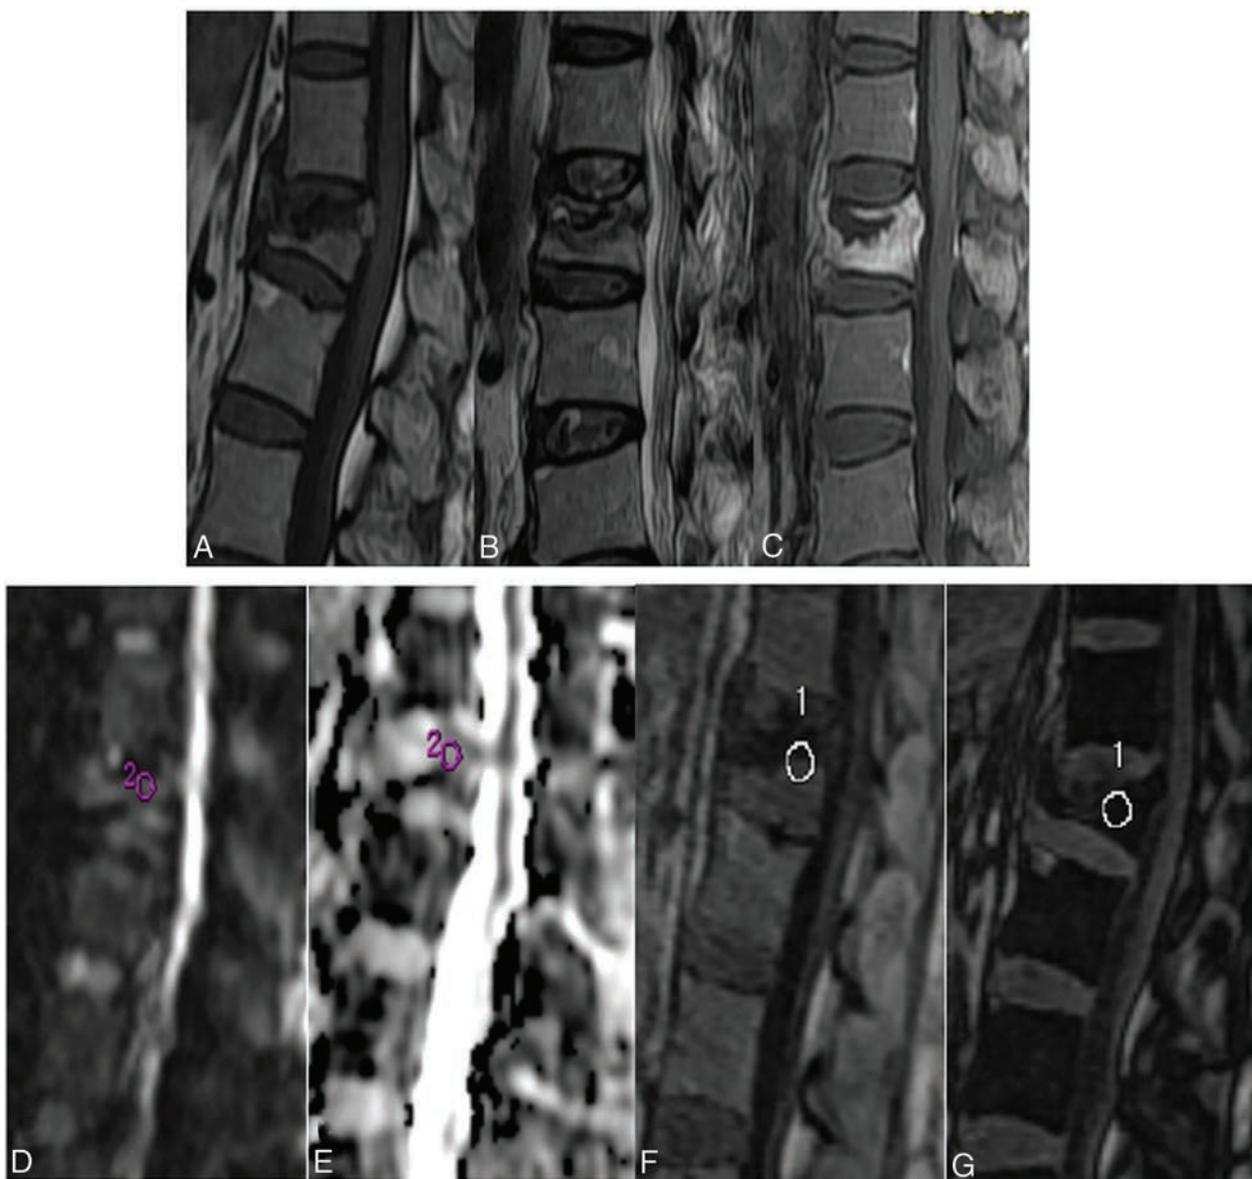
A 63-year-old woman with biopsy-proved osteoporotic vertebral collapse of the L1 vertebra shows partial collapse of the vertebra with retropulsion of the posterosuperior part of the vertebral body, the presence of the fluid sign, and the absence of prevertebral and epidural soft tissue on T1WI (A) and T2WI (B). The collapsed vertebra shows diffuse heterogeneous enhancement on the contrast study (C). Sagittal DWI obtained at the same level shows isointense signals (D). ADC measured from the L1 vertebral body is $1.3 \times 10^{-3} \text{ mm}^2/\text{s}$ (E). Sagittal in-phase (F) and opposed-phase (G) images with the ROI cursor drawn in the lesion are shown. The measured SIR is 0.56.
